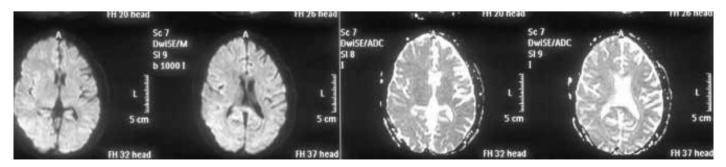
Magnetic resonance imaging showing atrophy of the left ventricle with ipsilateral ventricular dilation and atrophy of the caudate nucleus. Calcification and gliosis were absent
